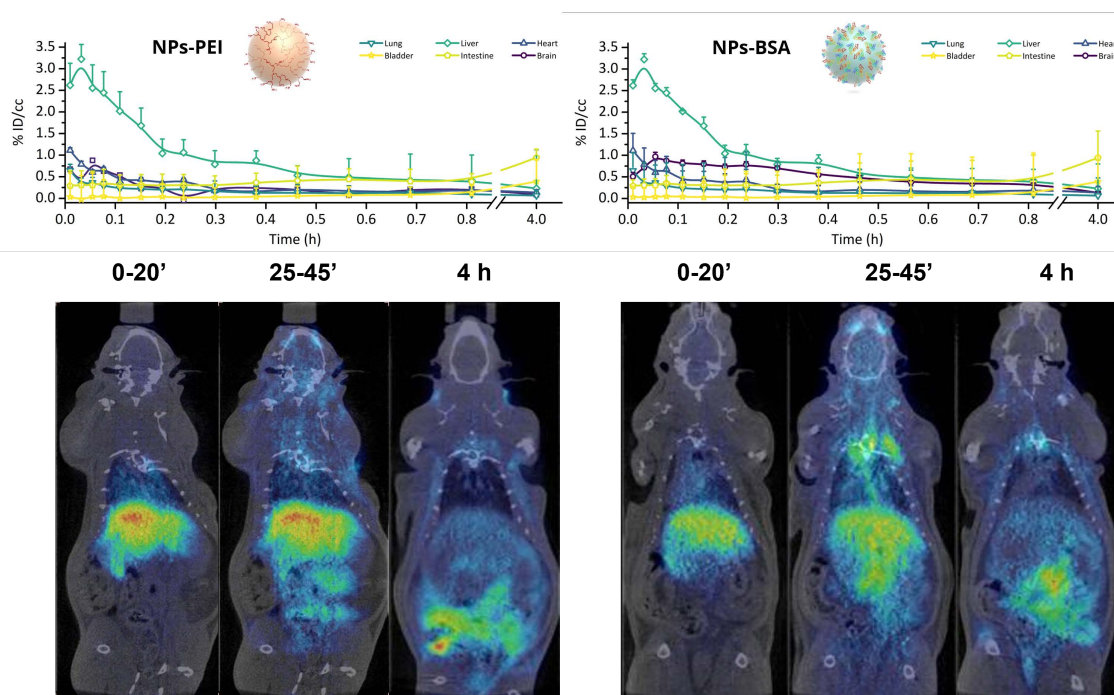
Concentration of radioactivity in different organs at different times after intravenous administration of PLGA NPs stabilized by PEI (left) and BSA (right). Representative PET-CT images (coronal slices) for different time frames are shown.
